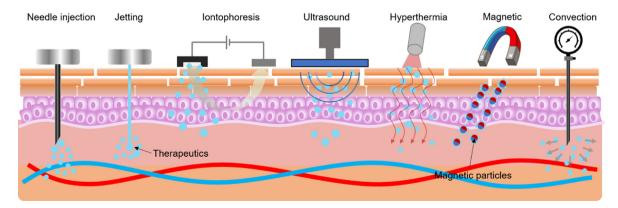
Overview of physical modes of drug delivery to the GI tract including needle injection, jetting, iontophoresis, ultrasound, hyperthermia, magnetic, and convection.
